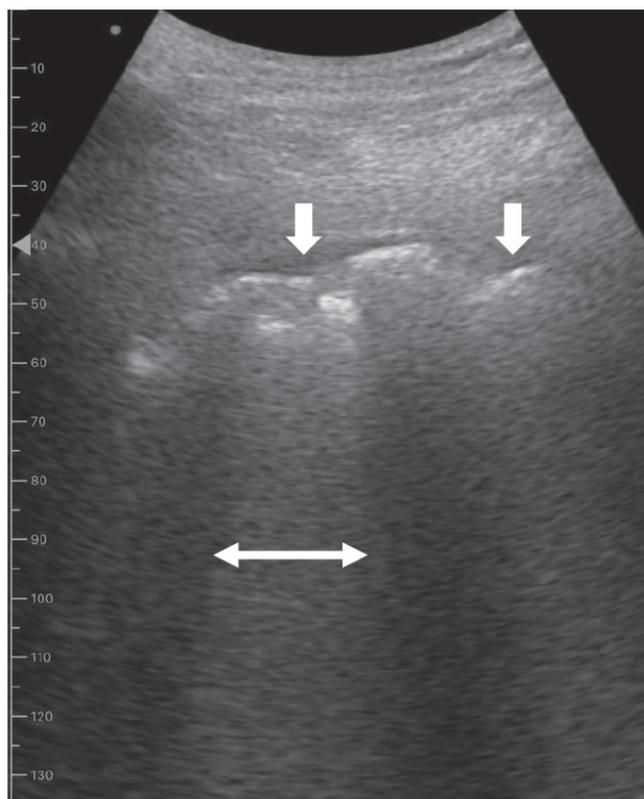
Lung ultrasound scan showing the small subpleural consolidations with areas of white lung. The pleura line is severely broken. Below the point of discontinuity, small consolidated areas (white thick arrow) appear with associated areas of white (double head arrow) in correspondence with the consolidations. The normal A-lines are not visible, nor single vertical artefacts. Conversely, a dense white area is visible below the pleural line (double head arrow).
